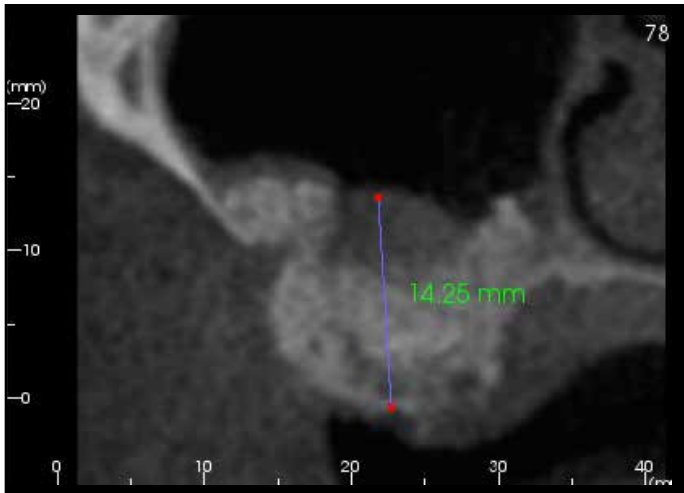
Postsurgical CBCT scan of the right maxillary sinus showing bone fill at 120 days.
